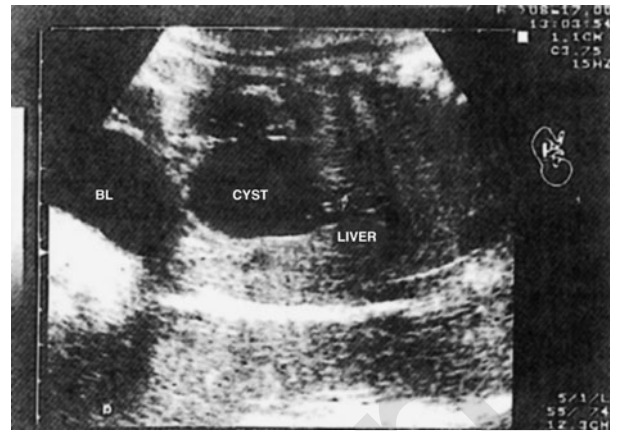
Antenatal ultrasound at 32 weeks' gestation. Sagittal view. A cystic structure is seen to be connected to the liver via a short duct (arrow). BL, bladder.
